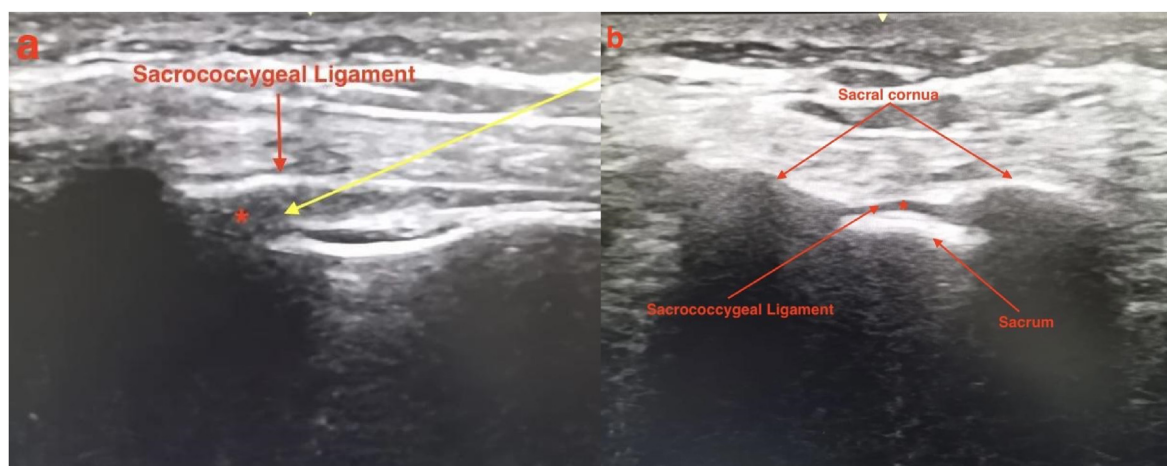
Sonographic images of the sacral hiatus (a) sagittal and (b) transverse view and epidural space (*).
